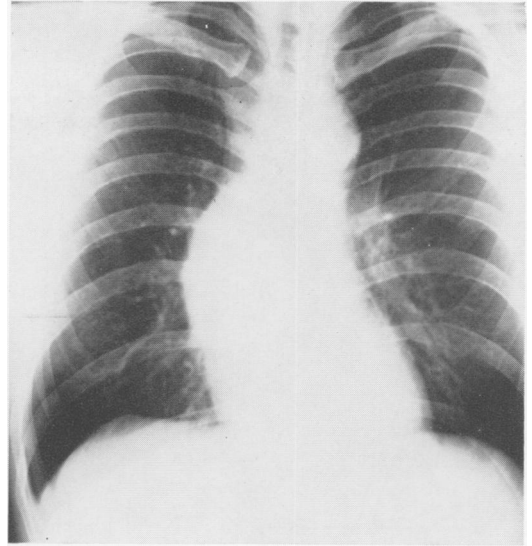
Case 4. 38-year-old carpenter with pain in anterior chest and neck three months previously. (a) Preoperative roentgenogram showing dilated ascending aorta, limited to this region and proximal arch as seen on angiocardiograms (b and c).
